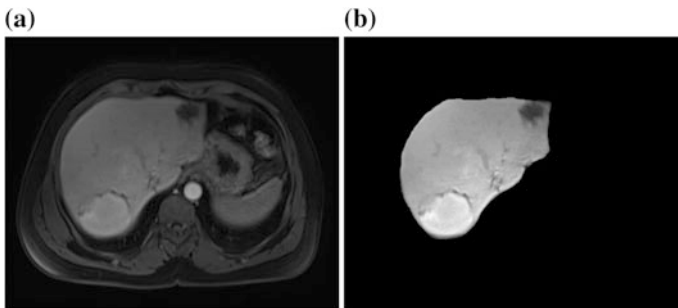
a Original liver MR image, b Segmented version
